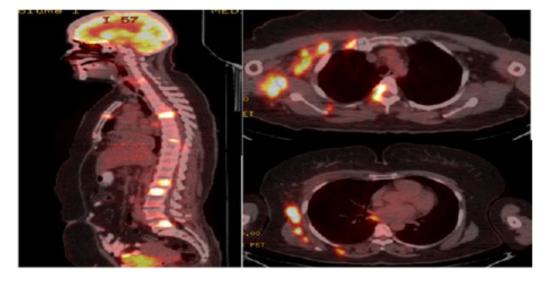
18 FDG whole body positron emission tomography (PET) findings.
